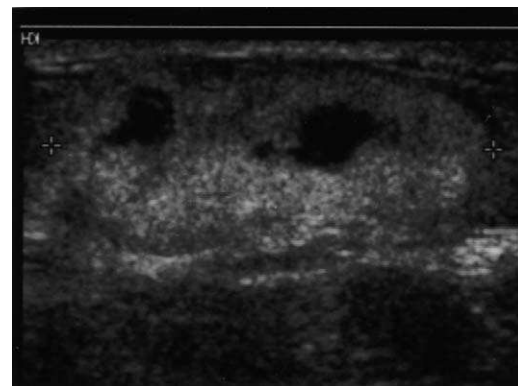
Breast hematoma. Calipers mark a heterogeneous, predominantly echogenic mass with multiple internal hypoechoic and anechoic cystic spaces. This patient presented a few days after a severe motor vehicle accident with a palpable lump and area of ecchymosis on the breast. Sonographic and clinical findings suggested presence of hematoma. Follow-up showed this area to resolve completely in 2 months.
